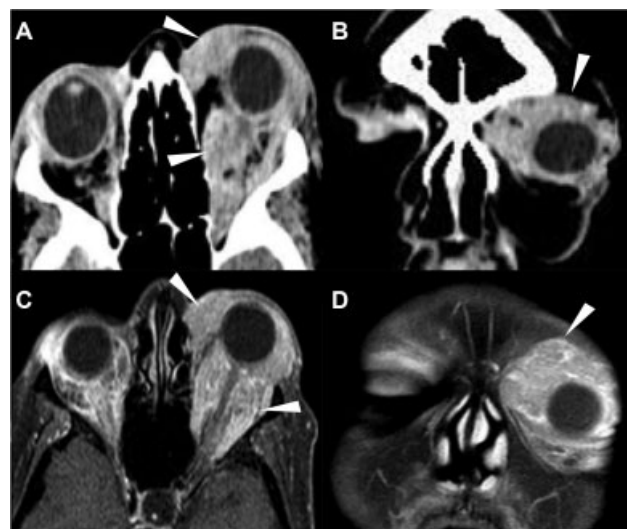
Orbital metastasis in computed tomography. A and B – Computed tomography without contrast shows thickening and densification of the periorbital soft tissues in the left orbit, with extension to the intraconal fat (arrows). C and D – Mass with left orbital infiltrative aspect showing intense enhancement after contrast, with intra- and extraconal components infiltrating the extrinsic musculature and involving the greasy planes and optic nerve, determining reduction of the caliber of the same and proptosis (arrows).
